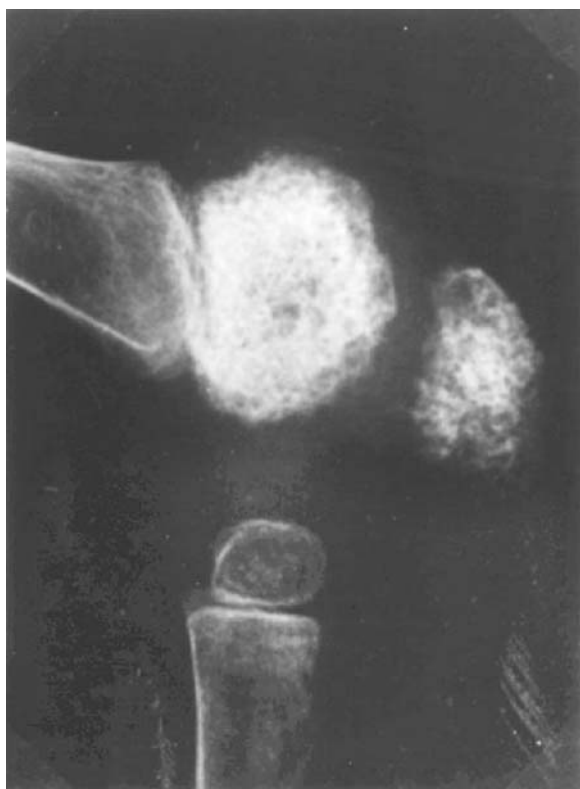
Radiographic appearance of arthropathy in NOMID/CINCA syndrome. (Courtesy of Dr. A.M. Prieur.)
